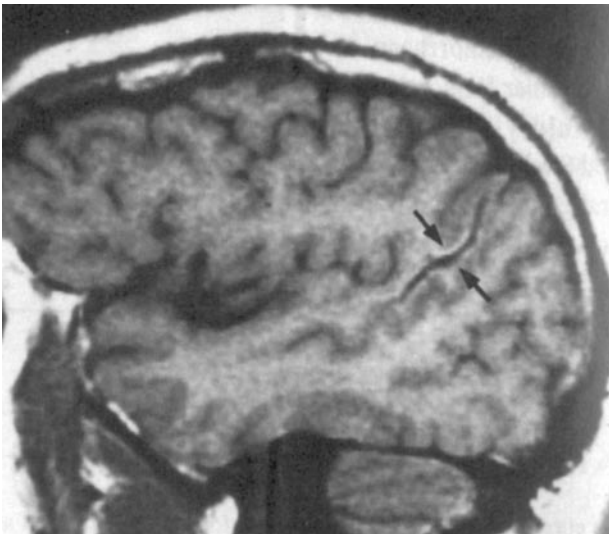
MRI hemosiderin cleft
